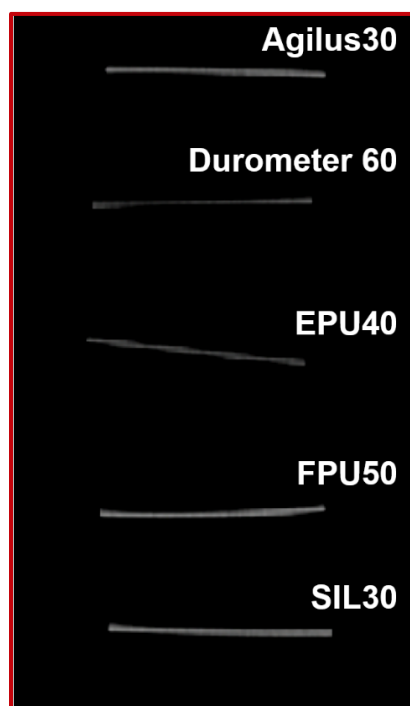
CT scan of five 3D-P materials; WW=400 HU, WL=40 HU.
